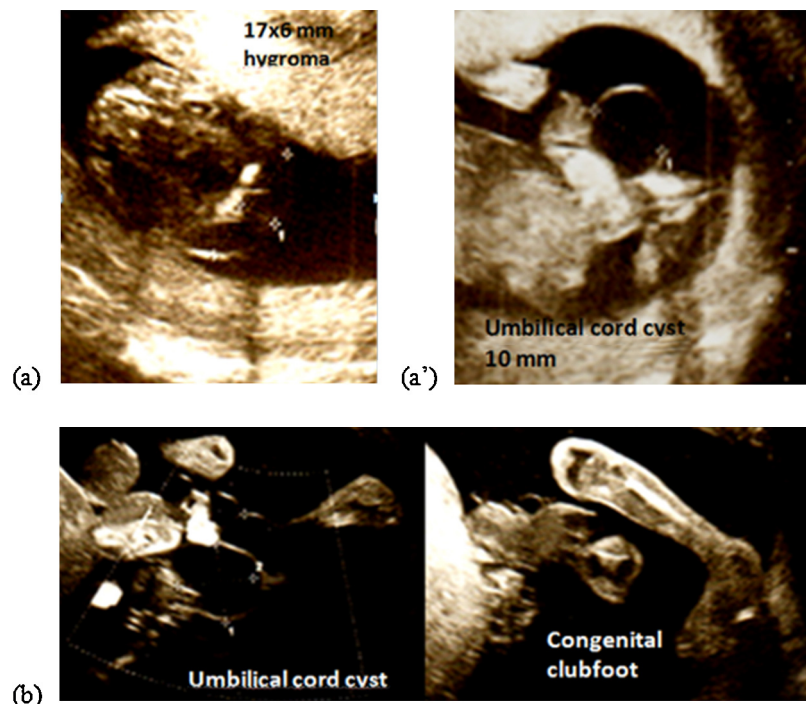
Septated retronuchal associated hygroma; prenatal diagnosis at first trimester (2009); hygroma disappearance at 16 weeks of gestation. Anasarca, umbilical cord cyst (47, XY + 18). TOP at 22 weeks in another hospital. Ultrasound at (a and a') 14 + 4 and (b) 17 + 5 weeks of gestation.
